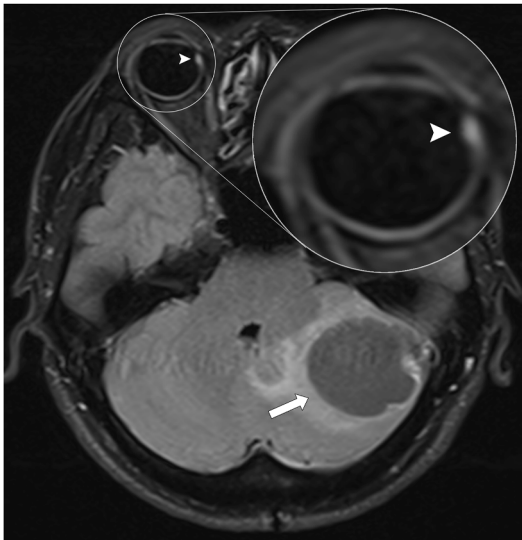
Axial T2-weighted FLAIR and fat-suppressed sequence of the brain shows an enhancing focus at the medial right retina suggestive of a retinal angioma (*arrowheads* and figure inset). A left cerebellar hemangioblastoma (*arrow*) is also present in this patient with von Hippel–Lindau disease.
